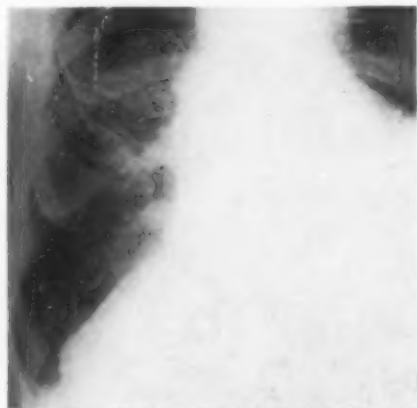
Roentgen ray examination of chest to show details in right lower chest. Note rounded shadows on lower parietal pleura and over diaphragm, and showing through lowermost part of the lung.
